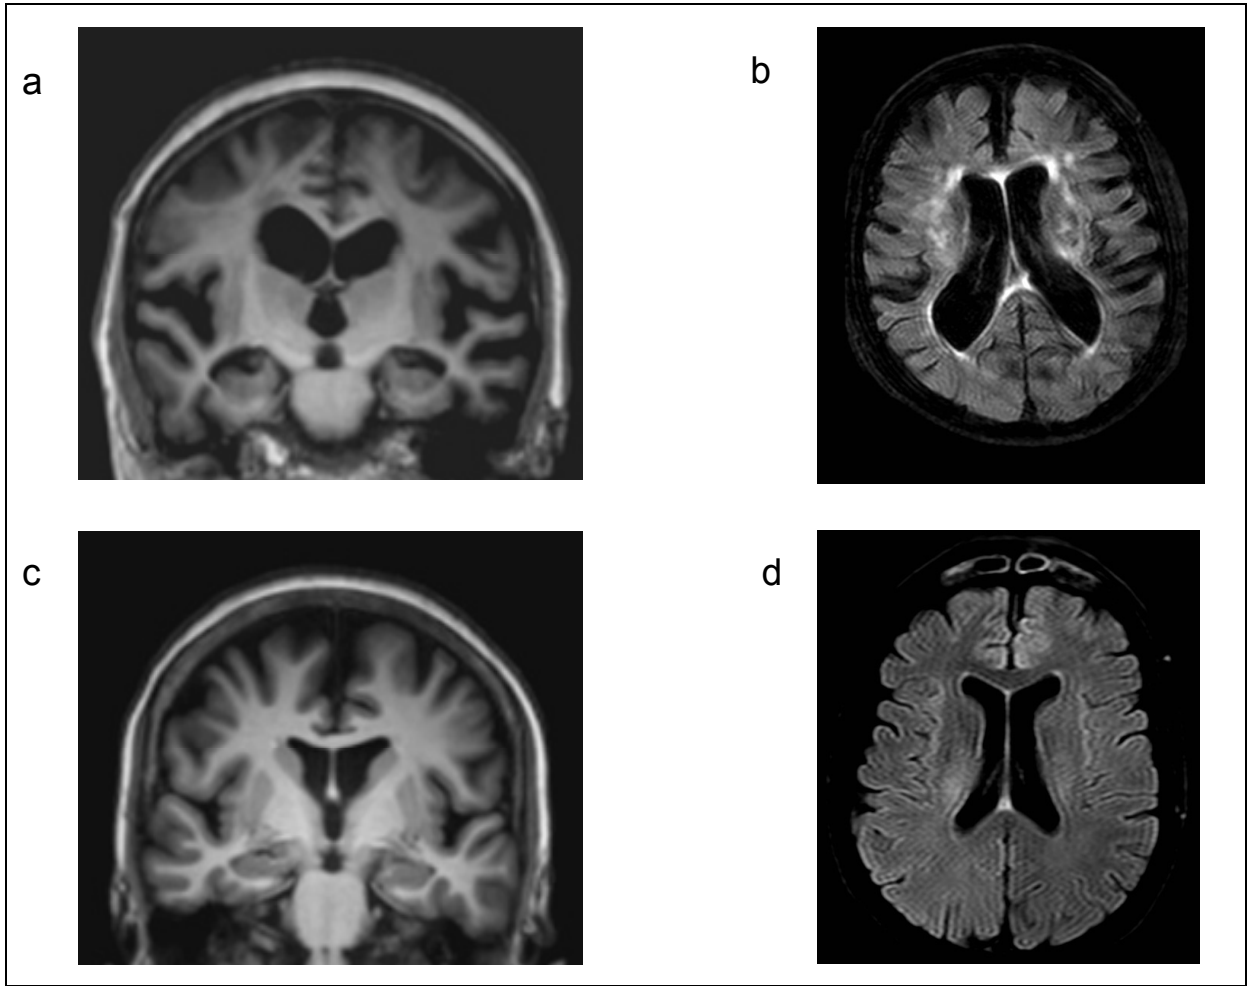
Magnetic resonance imaging findings of two female patients with dementia and FXTAS. A) Coronal T1-weighted, 3D MPRAGE MR image of patient 1 shows asymmetrical frontal, and bilateral, symmetrical, medial temporal atrophy. B) Axial 3D FLAIR of patient 1 shows marked hyperintensities in the cerebral white matter. C) Coronal T1-weighted, 3D MPRAGE MR image of patient 2 shows moderate cerebral atrophy involving the frontal lobes, while the medial temporal lobes appeared normal.; K) Axial 3D FLAIR of patient 2 shows no marked HI in the white matter.
